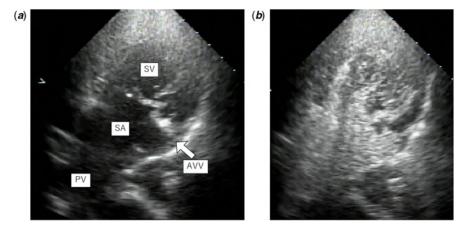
The example of bubble contrast echocardiography opacification before injection of microbubbles. There were no microbubbles in the cardiac chambers. After injection of microbubbles, the microbubbles immediately came into the cardiac chambers. We diagnosed this case as grade 3. AVV = atrioventricular valve; PV = pulmonary veir; SA = single atrium; SV = single ventricle.
